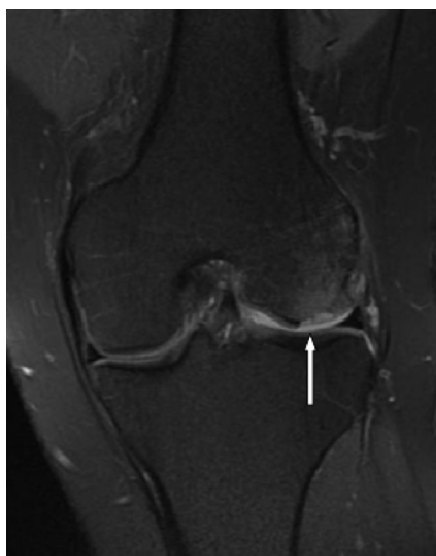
MRI coronal view left knee showing an osteochondral defect (arrow) at the lateral femoral condyle.
